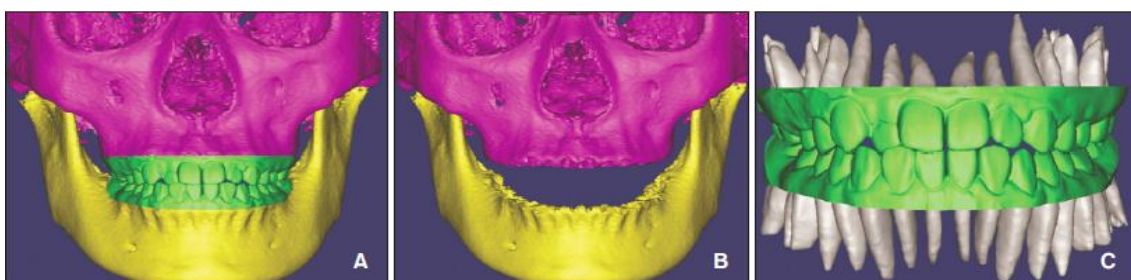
Integration of CBCT of the two maxillary arches (B), with the intraoral scan (A), so that root positions are calculated with crown position (C). (37)
